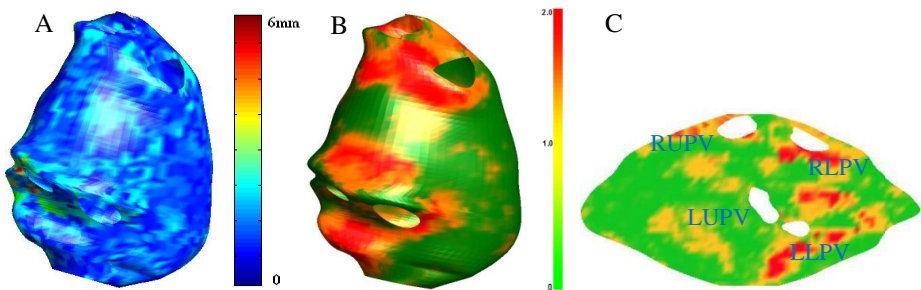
(A) Color map for surface fitting errors. (B) 3D lesion map created from the delayed enhancement MRI. (Scale for the color bar is the number of standard deviations from the mean of blood pool intensity.) (C) 2D unfolding lesion map.
